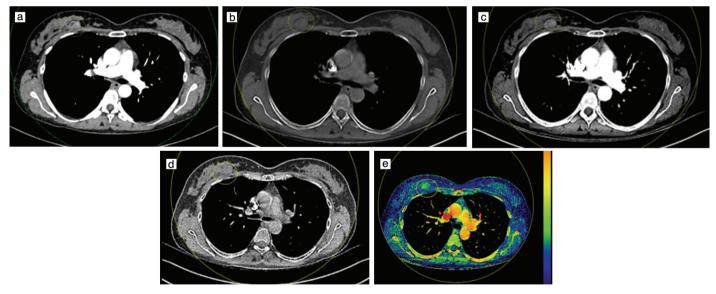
(a-e). Fusion axial slice formed by dual-energy CT (a), 190 keV axial slice (b), 40 keV axial slice (c), iodine-extracted axial slice (d), and iodine map (e). On the high keV (b) and iodine-extracted slices (d), the lesion (circle) is not visible, whereas on the fusion axial slice (a), distinguishing it from the surrounding tissue is quite difficult. The lesion can be easily noticed when looking at the low-voltage image (c) and iodine map images (e)
